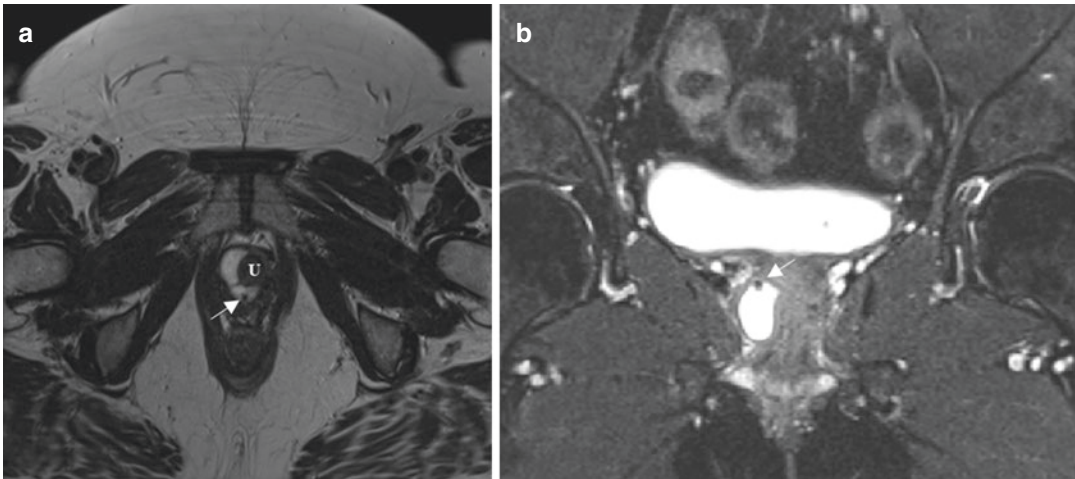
MR images of urethral diverticulum. (a) Axial T2-weighted MRI shows homogeneously enhancing elongated structure with thin septation along the right aspect of the mid-urethra consistent with urethral diverticulum.
